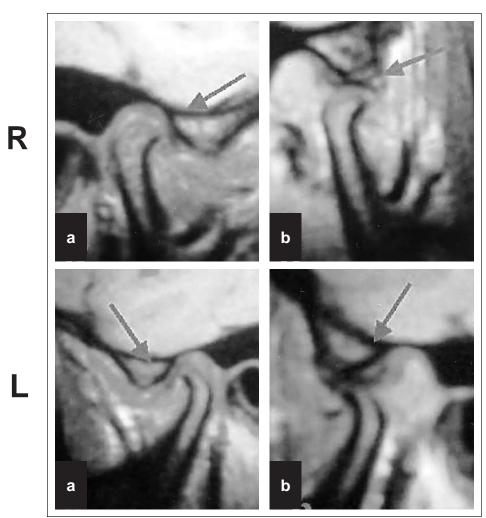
MRI show the bilateral re-establishment of normal condyle-disc relationships into maximum intercuspal relationships (Figure 5a) and during mouth opening (Figure 5b).
